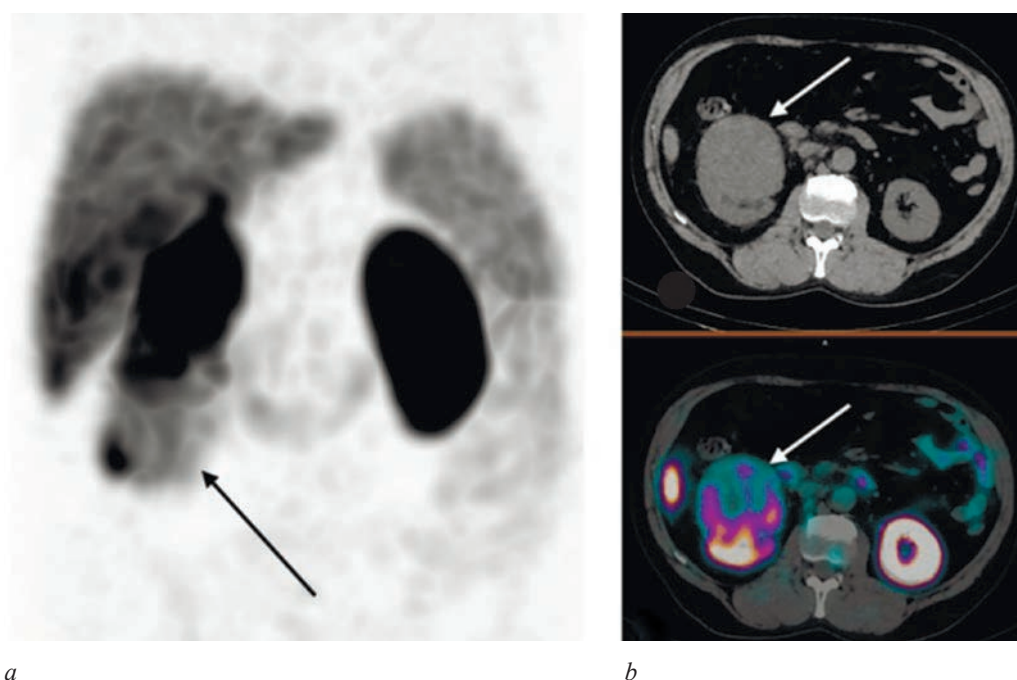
MIP- reconstruction (a), CT and combined SPECT / CT images (b) at 2 h after administration of [$^{99\text{m}}\text{Tc}$]Tc-HYNIC-PSMA in a patient with ccRCC, grade2: the arrow indicates the tumor, SUVmax 7.72 (self-reported).
